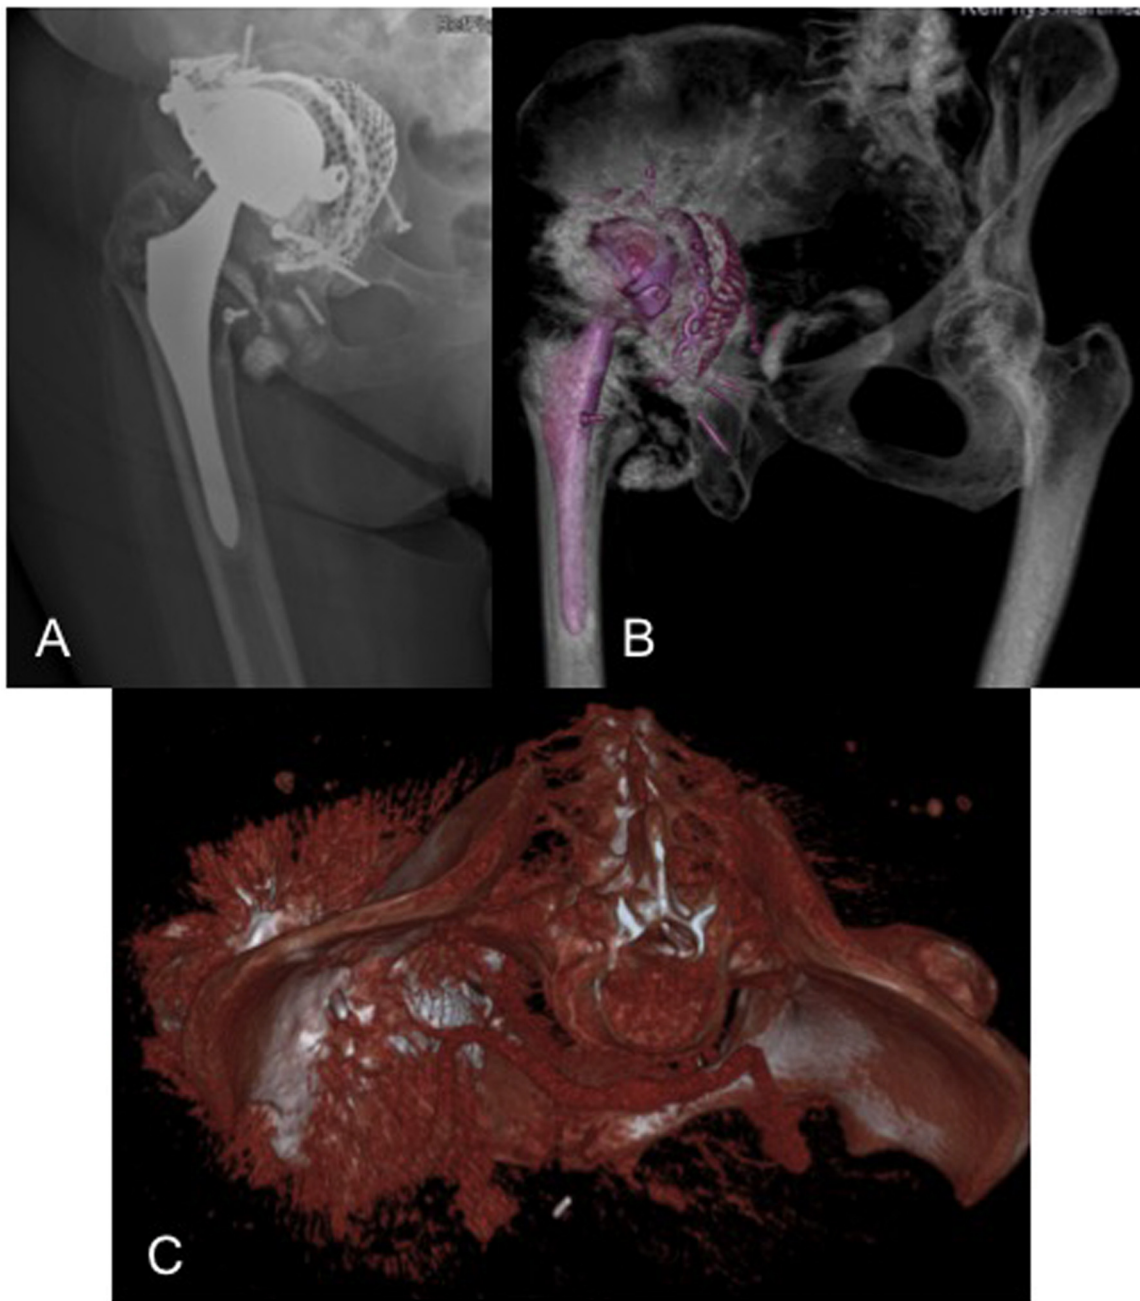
Radiological images: AP x-ray view (A); CT scan views showing the intrapelvic prosthetic migration (A) and its relationship with vessels (B).
